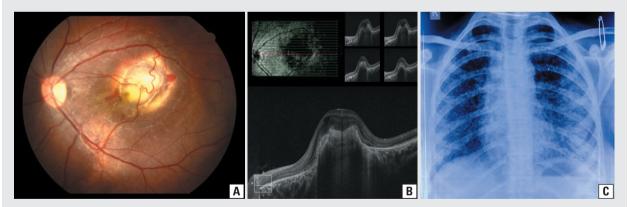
A. Fundoscopic examination of the left eye revealing a well-defined, subretinal, elevated, and oval-shaped lesion that was located on the macula. It had a 1.5 mm disc diameter (DD) that had overlying dilated vessels and adjacent oedema with subretinal haemorrhage, which was suggestive of a possible tuberculoma; B. Optical coherence tomography (OCT) of the macula of the left eye demonstrating an elevation of all the layers of the retina with parafoveal subretinal fluid and one intraretinal cystic space; C. Chest X-ray posterior-anterior view showing miliary shadows bilaterally suggestive of miliary tuberculosis
